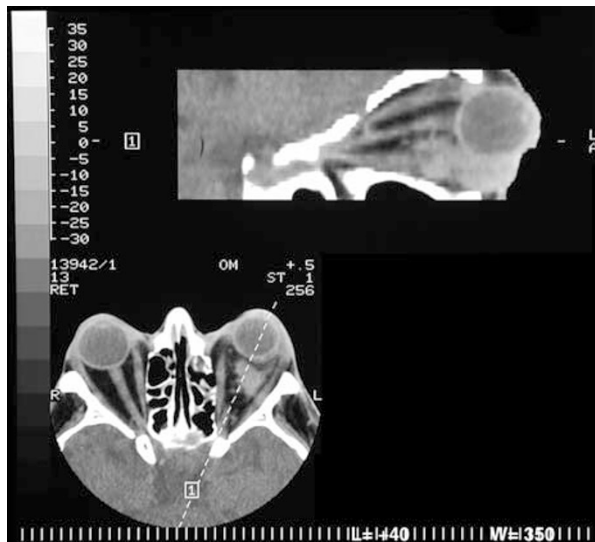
MR images demonstrating biopsy-proven lymphomatous infiltration of the left eyelid and anterior orbit, in the presence of bilateral diffuse extraocular muscle enlargement due to longstanding thyroid ophthalmopathy.
